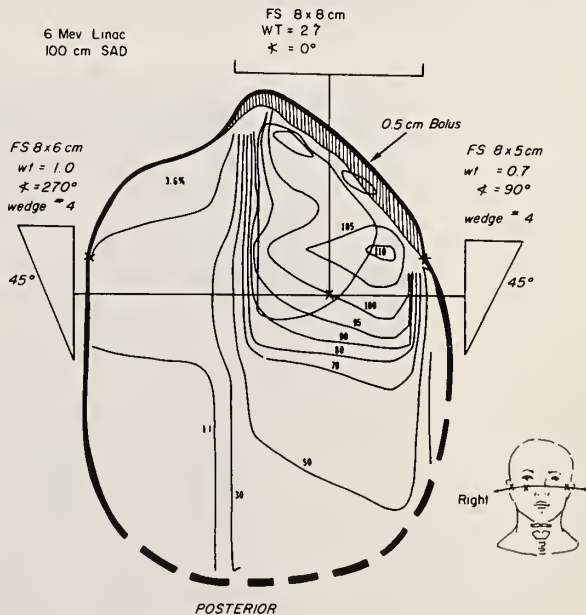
Patient treated for carcinoma of the right antrum using 6 MV X-rays.
